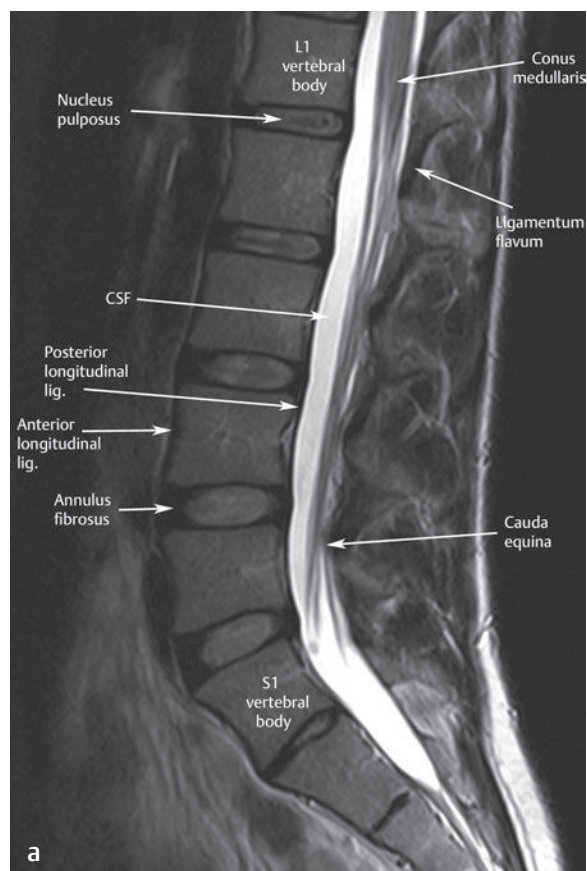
This (a) sagittal T2-weighted midline image and (b) artist's sketch of the lumbar spine show the conus medullaris and other important structures as identified. The posterior longitudinal ligament, intervertebral discs, and vertebral bodies are better differentiated on the T2-weighted images than on T1-weighted images.[†]
